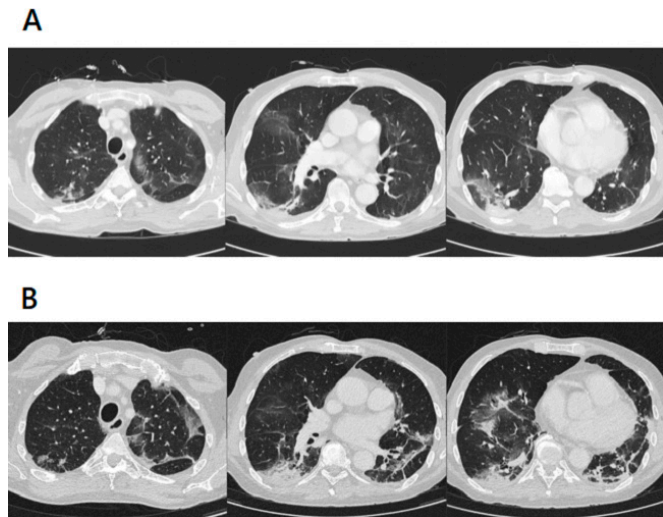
Thoracic CT scans. (A) First CT scan at initial presentation day 1 showing typical COVID-19 findings: multifocal, bilateral ground-glass opacities with superimposed interlobular septal thickening and consolidations in lung regions close to visceral pleural surfaces. (B) Repeat CT scan on day 13 showing worsening of the bilateral ground glass infiltrates and progressive consolidation of the right lower lobe, suggesting bacterial superinfection. Figure 1 by Silvan M Vesenbeckh.
